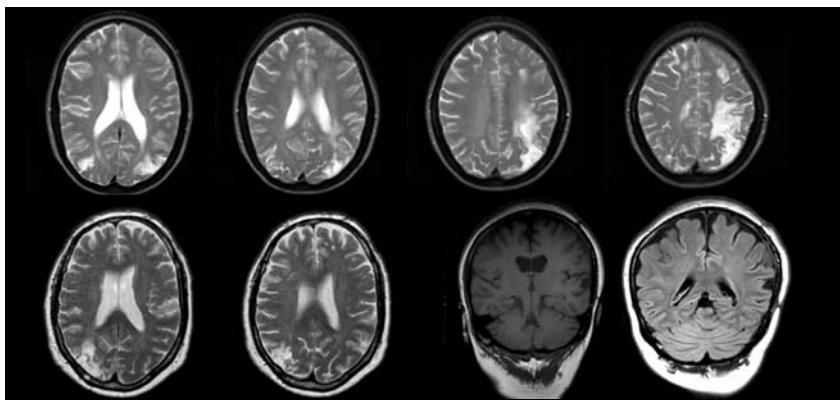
Scans of patient 1 [(A) MRI T2/FLAIR] patient 2 [(B) MRI T2/FLAIR] and the postoperative scan of patient 3 [(C) MRI T1]. MRI, magnetic resonance imaging.
